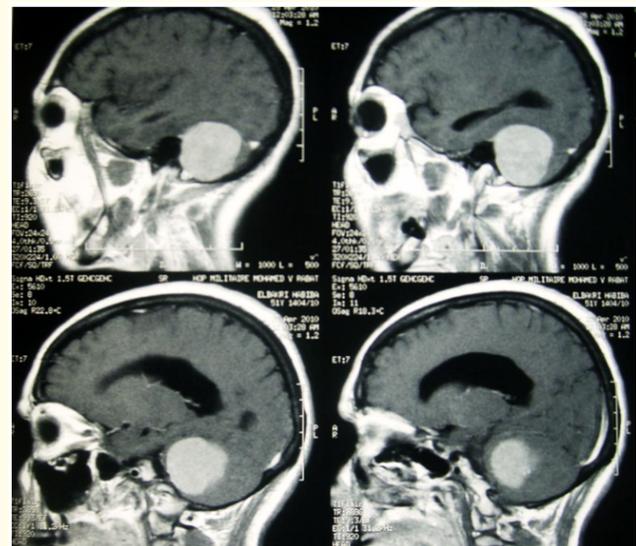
MRI showed an expanding cerebellar process, with enhancement after gadolinium administration.
